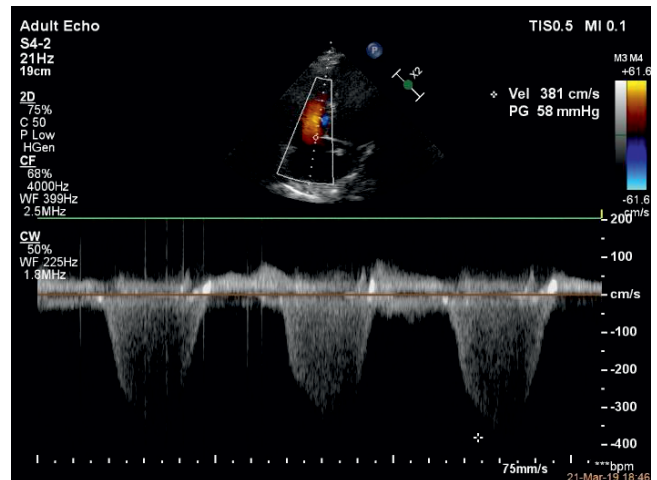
Transthoracic echocardiography, apical view, sPAP 63 mmHg.
